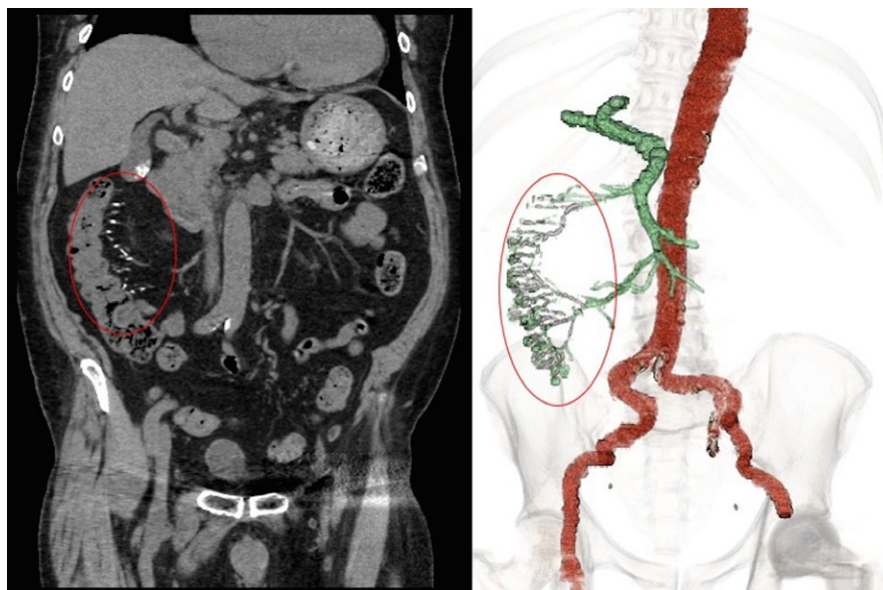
A computed tomography scan including a reconstructed image showed multiple linear calcifications distributed on the right-side mesenteric veins (red circles)
